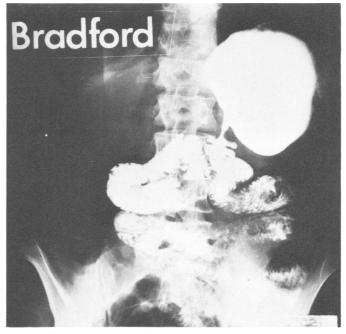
The only poor result from an antiperistaltic jejunal segment. The interposed segment was too long (18 cm.). Over a 4-year period multiple ulcers and stenosis developed as shown in x-ray. After replacing this segment with 8 cm. long segment, patient did well.
